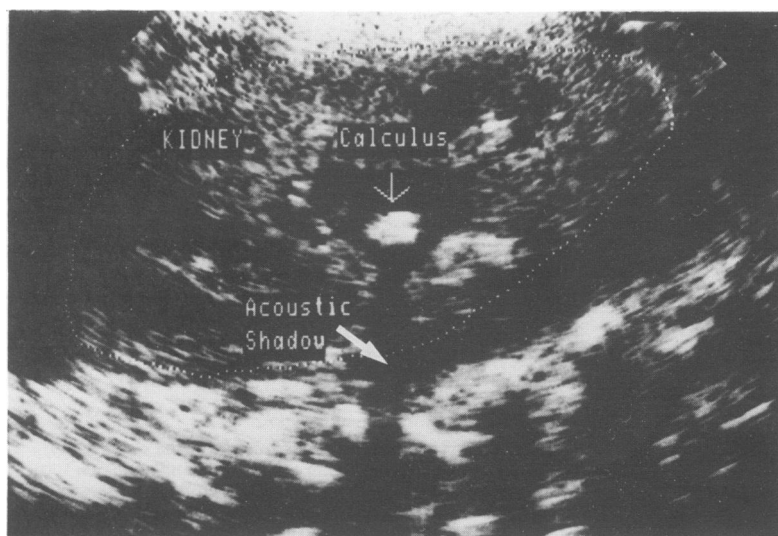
Ultrasound scan demonstrating a renal calculus in the left renal pelvis with accompanying acoustic shadowing. This patient was treated with regular frusemide from 11 days of age.
